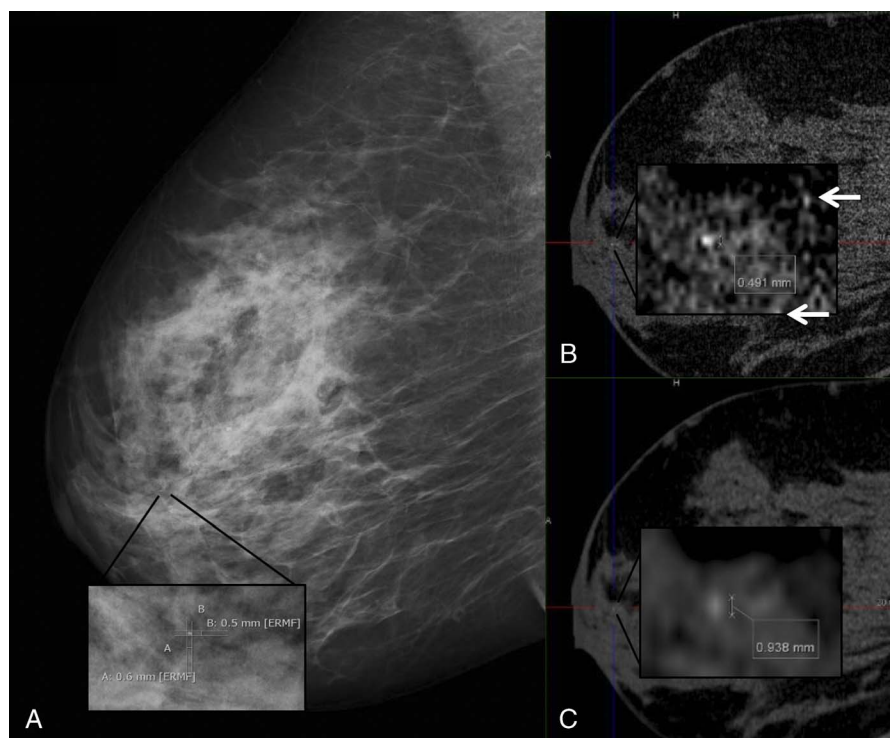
Same woman as in Figure 2. A microcalcification is visible in the mediolateral oblique mammogram in the retroareolar region and magnification is provided (A). Mammography was performed 24 months before B-CT. HR (B) and ST (C) and corresponding magnification of the microcalcification are provided. In HR magnification, additional microcalcifications can be recognized (white arrows). Although the 2 examinations were performed in a long time-interval and variation of calcification size could have occurred, similar values of minimum diameter were measured in mammogram and HR. In ST, the minimum diameter was 0.3 mm larger than in HR.
